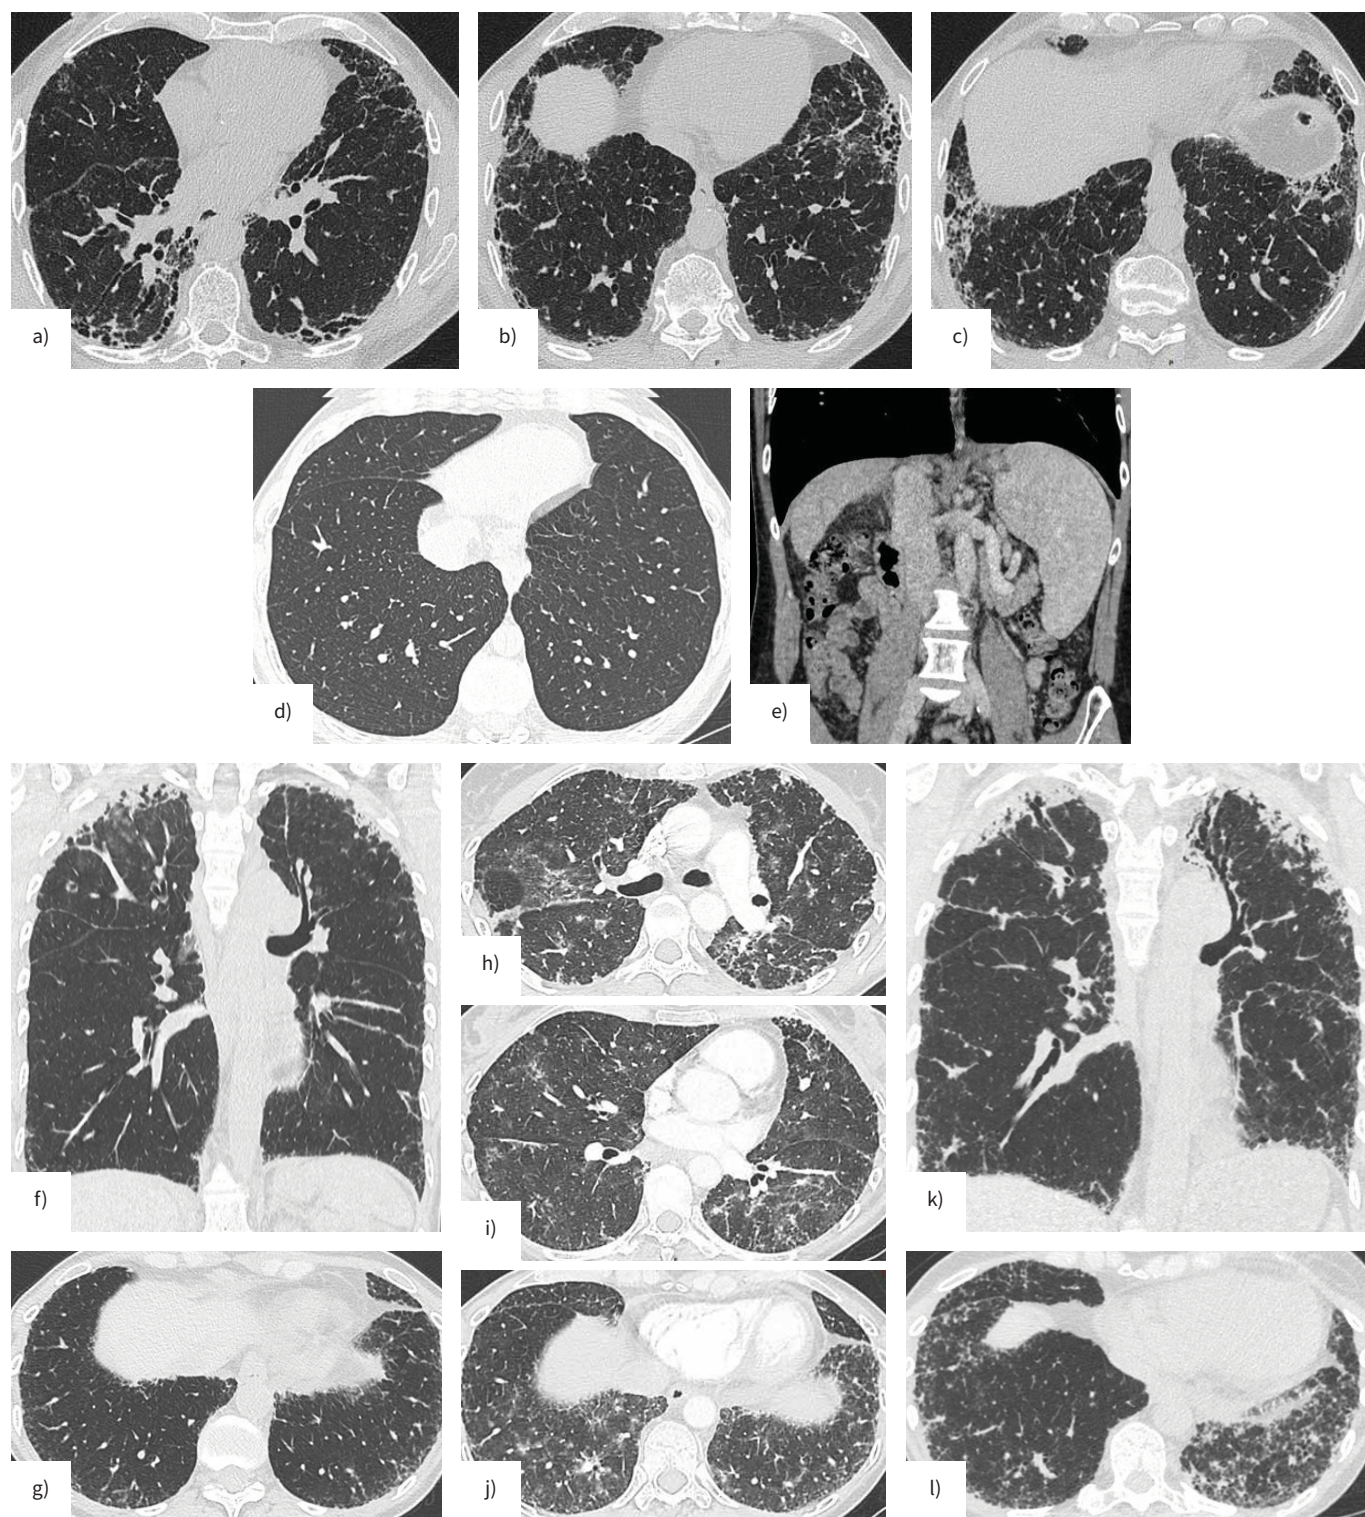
Computed tomography (CT) patterns associated with telomere-related gene mutation. a, b and c) Usual interstitial pneumonia pattern (UIP) in a 67-year-old *TERT* mutation carrier. d and e) Hepatopulmonary syndrome in his 34-year-old *TERT* mutation carrier son without interstitial lung disease, related to liver cirrhosis (e) splenomegaly and signs of portocaval collateral veins). f) CT scan suggestive of pleuroparenchymal fibroelastosis (PPFE) in a 47-year-old nonsmoking *TERC* mutation carrier with associated mild subpleural reticular opacities in the lower lobes (g). h, i and j) Acute respiratory failure a few months after diagnosis related to *Pneumocystis jirovecii* infection with initial improvement but evolving to progressive pulmonary fibrosis, involving both the subpleural apical consolidations related to PPFE 5 years later and the lower reticular opacities, indeterminate for UIP (k and l).
